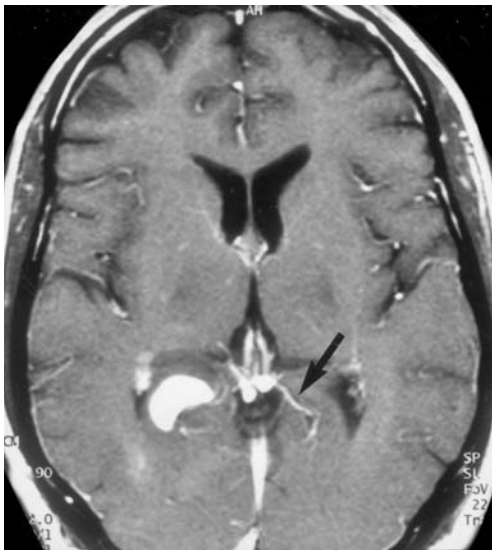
A 55-year-old man suffering from recurrent blurred vision. Diagnosis: primary malignant CNS lymphoma. MRI: a Axial T2-weighted view identifying enhancement of the right occipital paraventricular gray matter with slight perifocal edema. b Corresponding T1-weighted native view. c Corresponding T1-weighted, contrast-enhanced view with intense, homogeneous signal enhancement in the region of the right calcarine sulcus with compression of the trigone of the ipsilateral ventricle. Note the sulcal location of the left calcarine vein (*arrow*) draining into the distal left internal cerebral vein. d Coronal T2-weighted (FLAIR) view, demonstrating the relation of the tumor (intermediate signal) and perifocal edema (bright signal) to the calcarine sulcus (*arrows*). e Corresponding T1-weighted, contrast-enhanced view. f Paramedian sagittal, T1-weighted, contrast-enhanced view demonstrating additional, exclusively intraparenchymal tumor infiltration of the cuneus, possibly as a result of growth along the parieto-occipital sulcus
